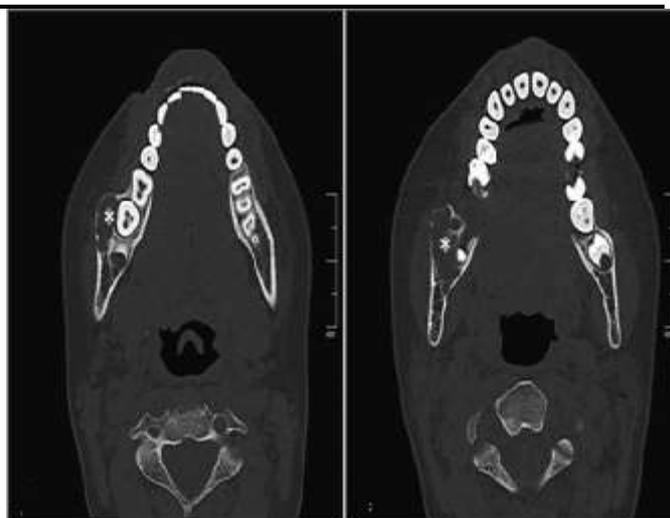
Showed imaging section of upper and lower jaw by using Dental computed tomography (CT) (Eyselbergs, et, al. 2014).
